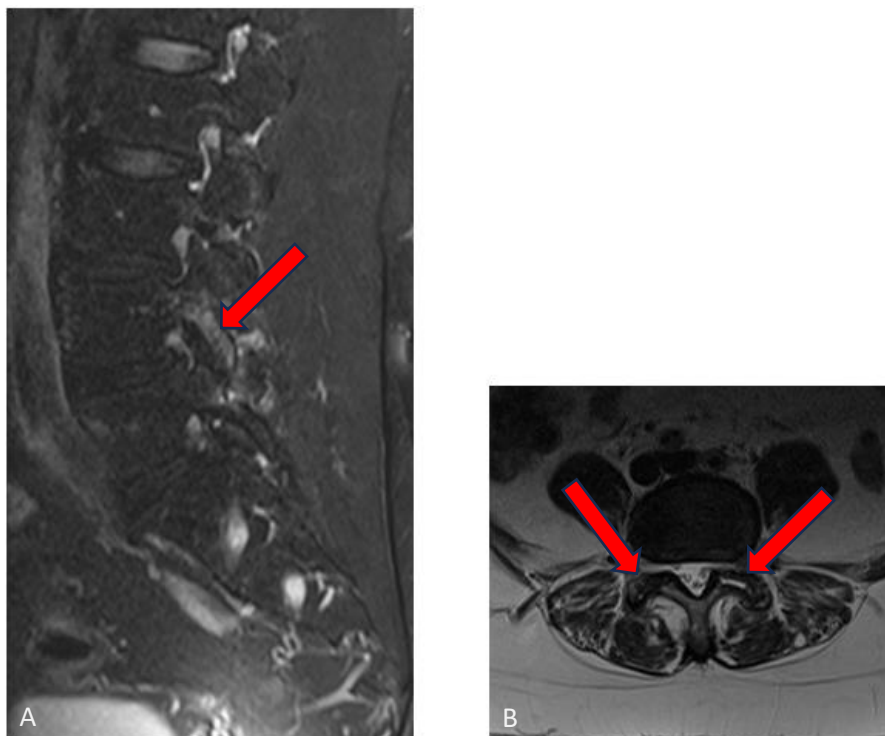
A-B: *MRI sagittal (A), axial (B): facet syndrome (arrows).*
